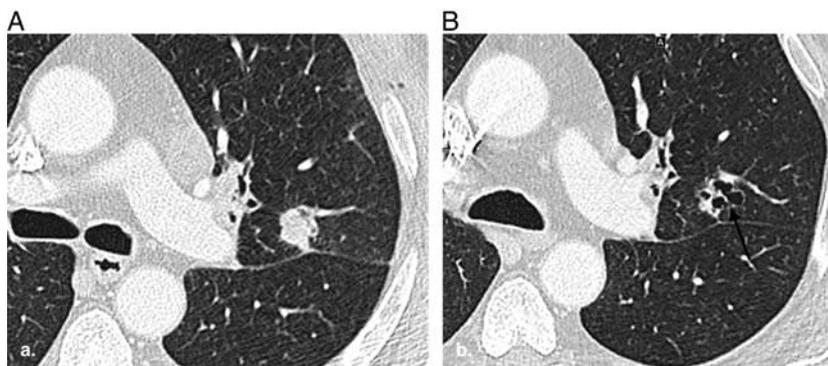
Cavitory response with the use of antiangiogenic agents. A, Baseline contrast-enhanced axial CT image shows a solid NSCLC in the left lung. B, Follow-up contrast-enhanced axial CT image obtained after 6 months of therapy with an antiangiogenic agent, demonstrating no significant overall change in size of lesion but new central cavitation (arrow).
